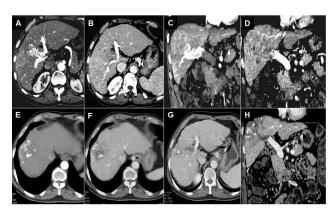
(A–H) HCC with Vp1 type PVT: baseline CT images in the noncontrast axial phase image (A), arterial phase axial (B), portal venous phase axial (C), and portal venous phase coronal image (D) showing a large lesion in segment VIII of liver displaying arterial phase enhancement and venous phase washout suggestive of HCC with associate Vp1 PVT. Post-TACE follow-up CT noncontrast axial (E), arterial phase axial (F), portal venous phase axial (G), and portal venous phase coronal image (H) showing complete lipiodol deposition and no any enhancement s/o complete response. CT, computed tomography; HCC, hepatocellular carcinoma; PVT, portal vein tumor; TACE, transarterial chemoembolization.
